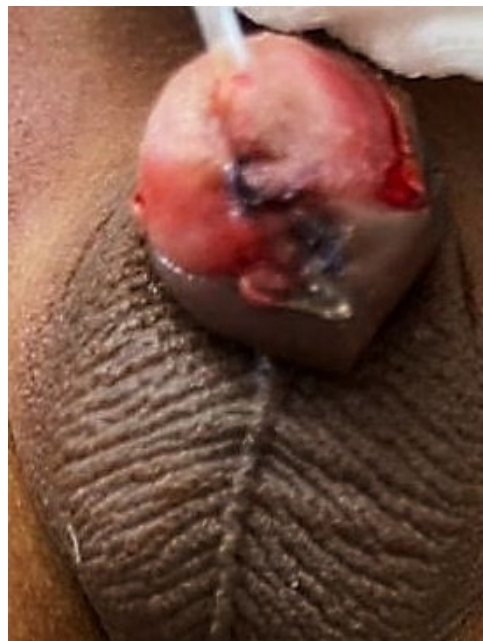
Post circumcision phimosis and meatal stenosis with a buried penis/penile entrapment in a two-year-old Boy after circumcision by a traditional circumciser. Some wetness from a urine spurt can be observed over the skin of the perineum on the patient's right side. This came from a forced urine jet that spurted as the patient strained to urinate (through the pin-hole meatus) during gentle physical examination. The bladder was not distended on physical examination. There was no bladder distention or hydronephrosis on ultrasound.
